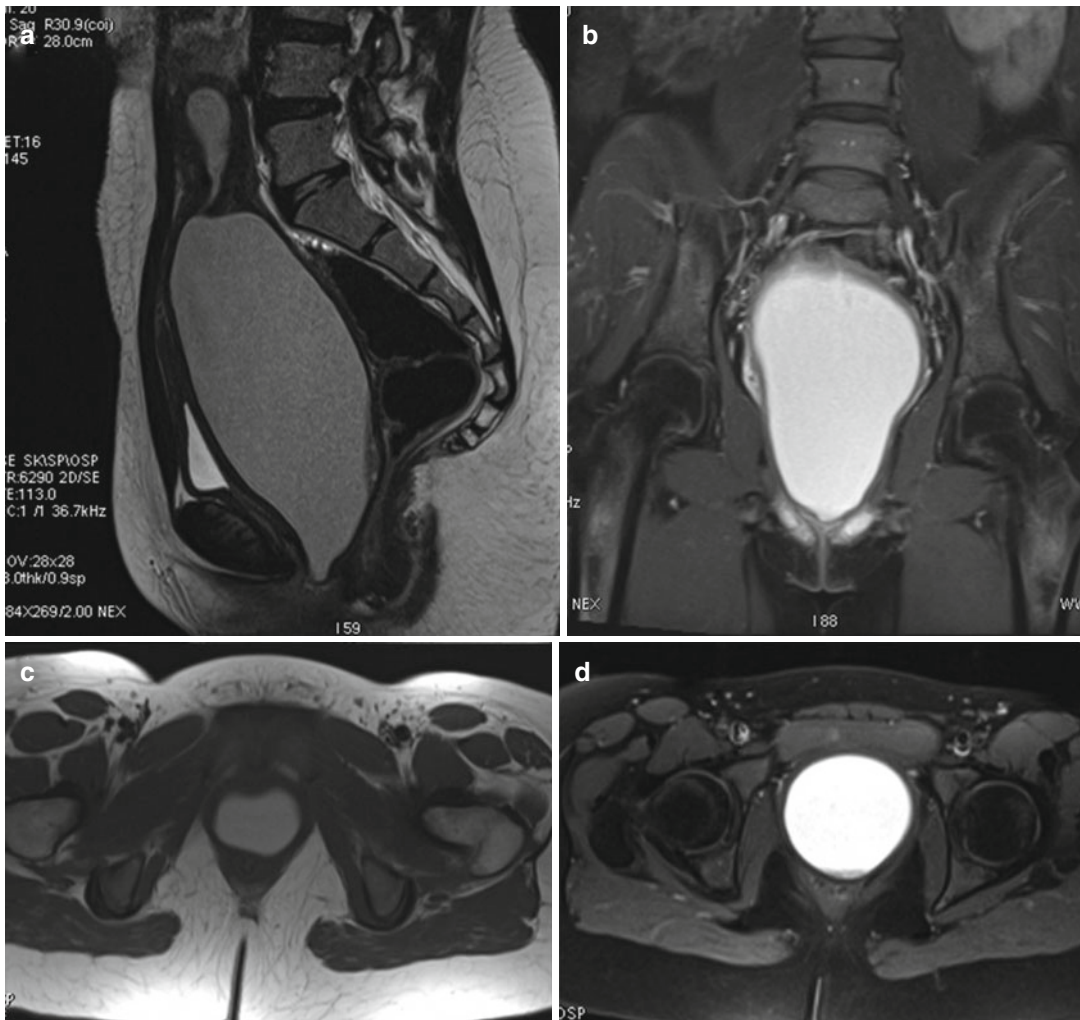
(a–d) The MRI shows a large pelvic mass due to the significant expansion of the vagina cavity because of a massive collection of blood material mass appearing
